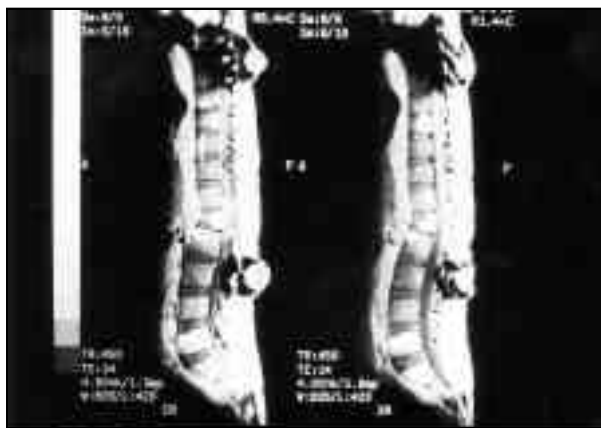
Spinal MRI showing a wedge shaped compression fracture of L1, post contrast enhancement in the bodies of T9, T12, L1, L2 and L5 vertebrae. There is no epidural invasion or cord compression. Also shown, is the spinal gibbous.
